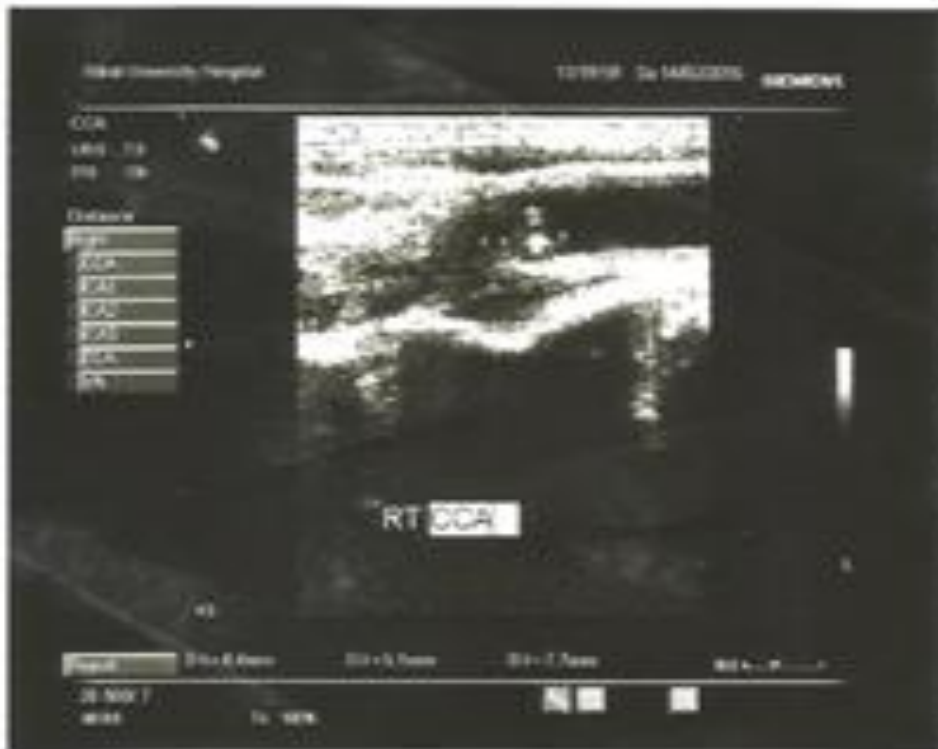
Rt CCA- female- 50 years diabetic patient with normal Doppler parameters.
